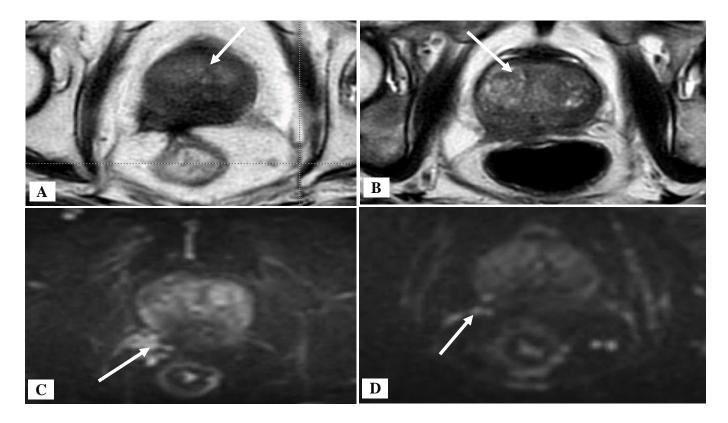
Axial MRI T2 and diffusion weighted images post-radiotherapy in a case of metastatic castrate resistant prostate cancer. Figure 9 shows reduced prostatic signal intensity denoting excellent radiation response (A, B- white arrow) and regression of prostatic mass 3.8*3 cm with restricted diffusion (C- white arrow).
